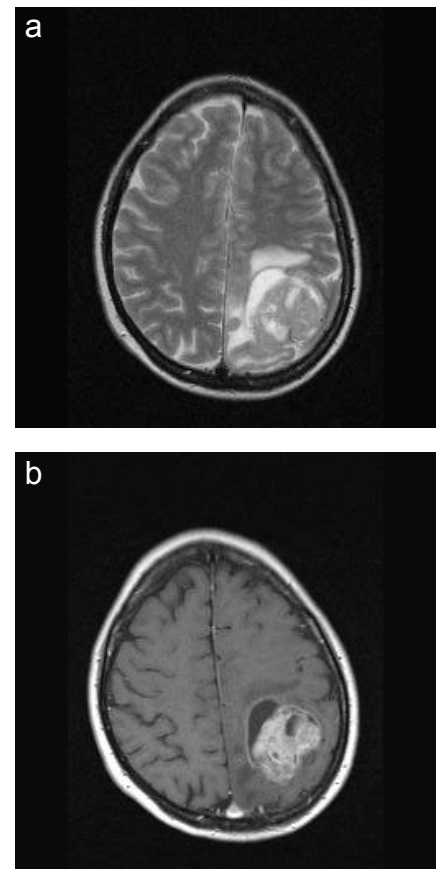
(a) Magnetic resonance imaging scan of the head showing the radiological appearance of left-sided parietal primary rhabdomyosarcoma on T2-weighted and (b) T1-weighted images after Gadolinium administration
